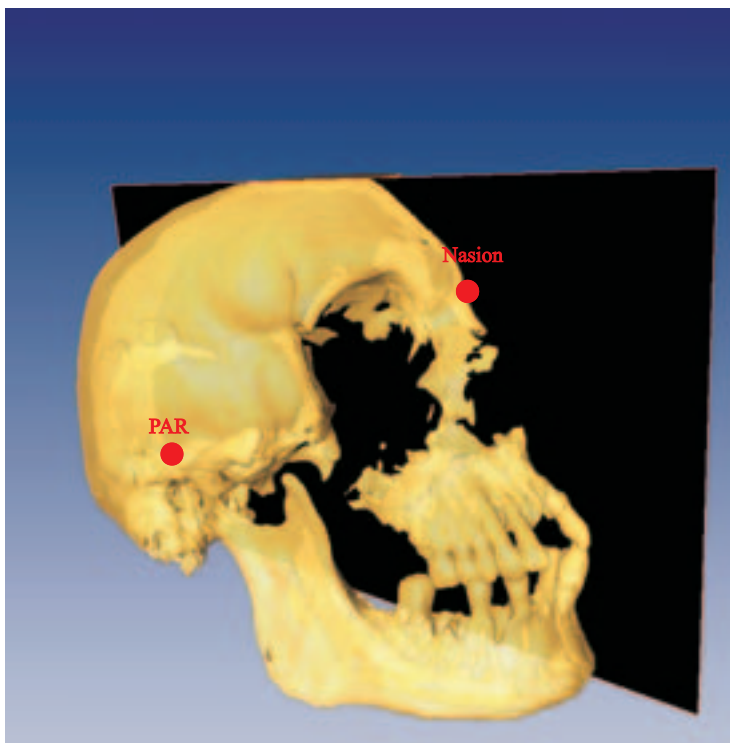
3D-CT des Schädels des Herzogs von Sachsen, Widukind, spätes 8. Jahrhundert.
